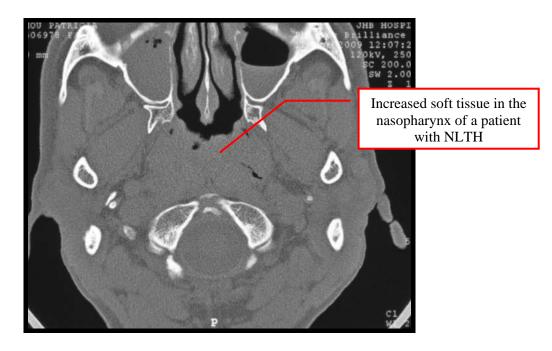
CT- Axial cut through the nasopharynx showing a benign tumour.
